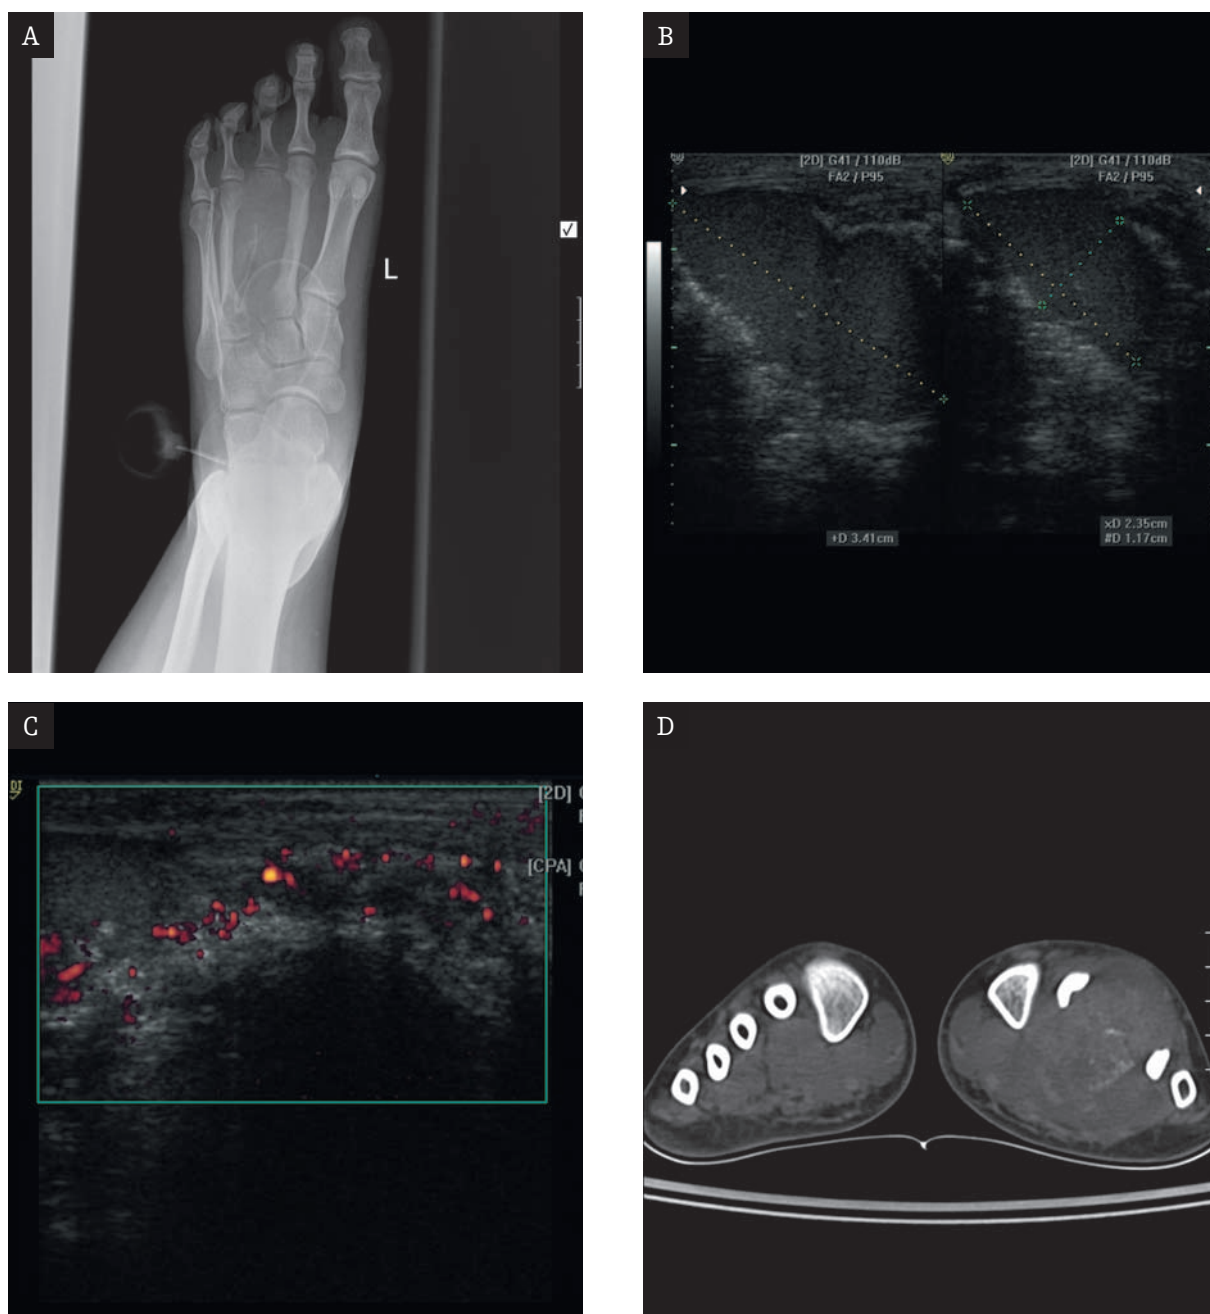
PNET of the 3rd metatarsal bone of the left foot. A. Plain film. Nearly total osteolysis. A big tumor after biopsy, drainage in the soft tissues. B and C. US. Homogenous, clearly demarcated mass in the diaphysis, bone destruction and calcification, pathological vessels among calcifications. D. CT. Nearly total osteolysis, a big, contrast-enhanced tumor in the soft tissues. Deformation and infiltration of the adjacent bones.
